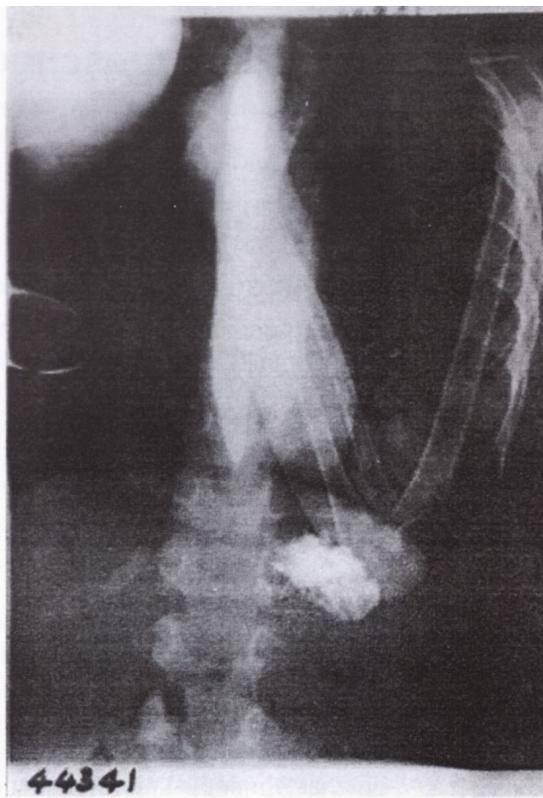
Barium swallow x-ray showing the characteristic tapering "breaking" at the gastro oesophageal junction
